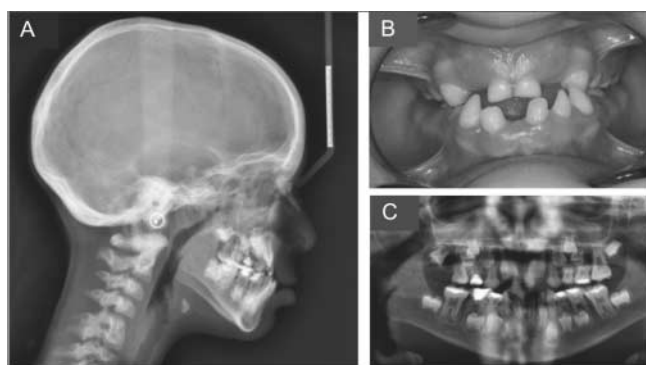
(A) Pretreatment cephalometric radiograph: maxillary skeletal retrusion, obtuse nasolabial angle, low midface length (height), high mandibular plane angle, retroclined maxillary incisors. (B) Pretreatment intraoral photograph: persistent deciduous teeth. (C) Pretreatment panoramic radiograph: lack of 16, 12, 22, 42 teeth, prolonged crowns and shortened roots of 26, 36 and 46 teeth.
